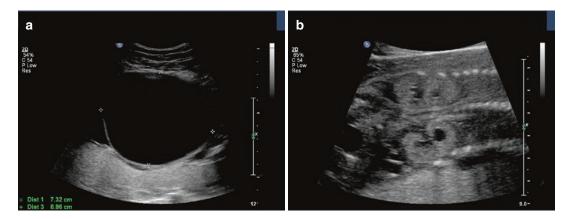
(a) Antenatal ultrasound (20 + 4 weeks) showing massively dilated and tense bladder. (b) Echogenic kidneys with caliectasis
